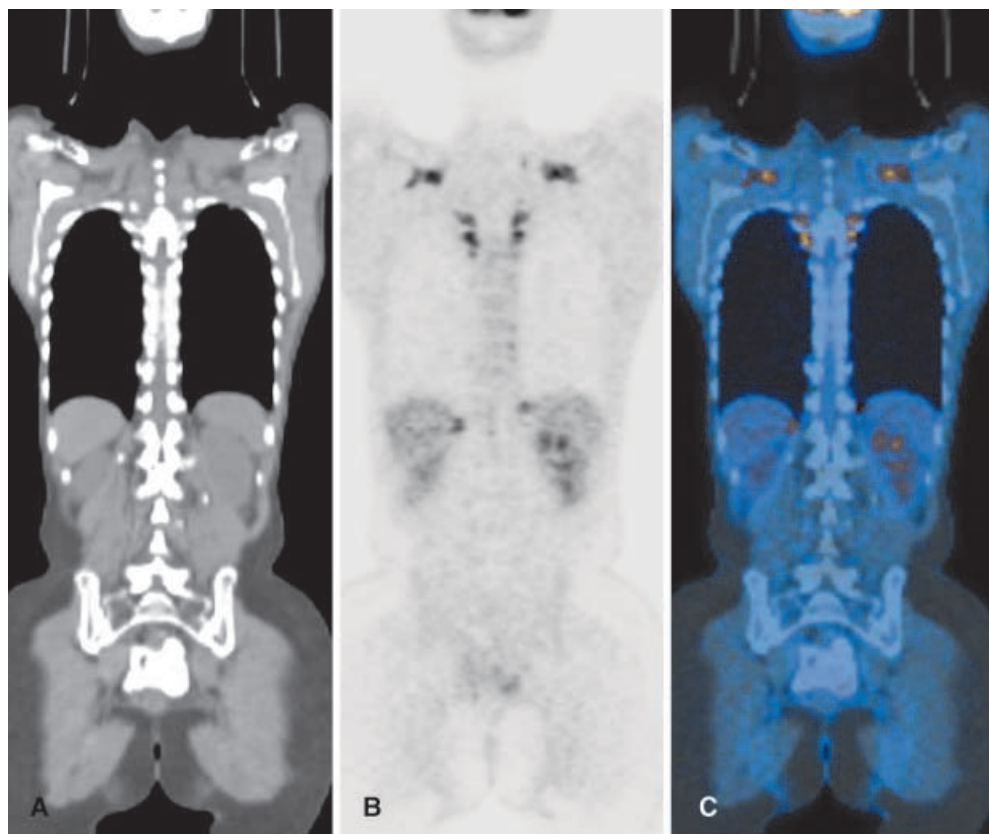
Axial PET (A), CT (B) and co-registered PET/CT images in the same patient as in Fig. 1. FDG is located in the soft tissue in the region of the costovertebral joints (C)
